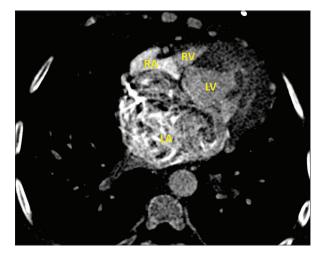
Axial section from computed tomography angiogram shows severe hypoplasia of the right atrium and right ventricle. The right atrial appendage is that of right atrial morphology confirming usual arrangement of atriums
